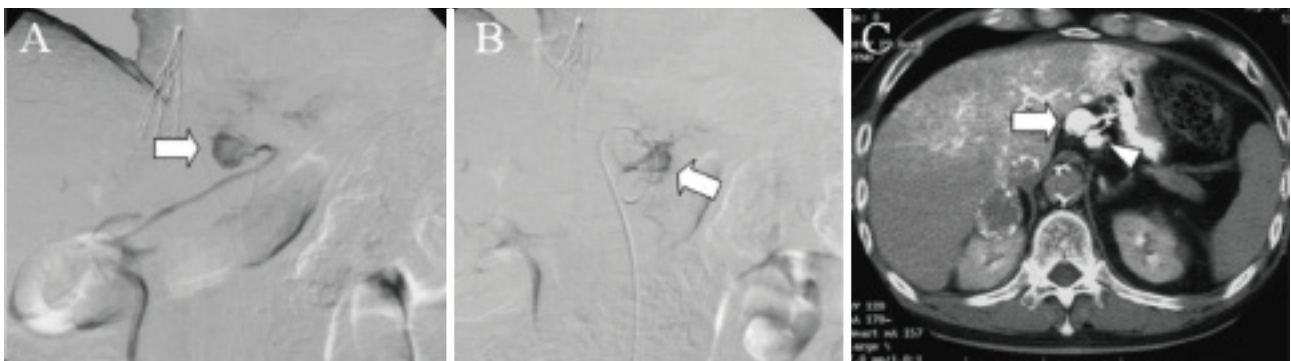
A: A tumor (arrow) detected in a lymph node along the lesser curvature of the stomach on an arteriogram of a feeding vessel from the left gastric artery; B: A tumor (arrow) seen in a lymph node along the left gastric artery on an arteriogram of another feeding vessel from the left gastric artery; C: Enlarged lymph nodes detected along the lesser curvature of the stomach (arrow) and along the left gastric artery (arrowhead) on computed tomography during a hepatic arteriogram of the celiac artery.
